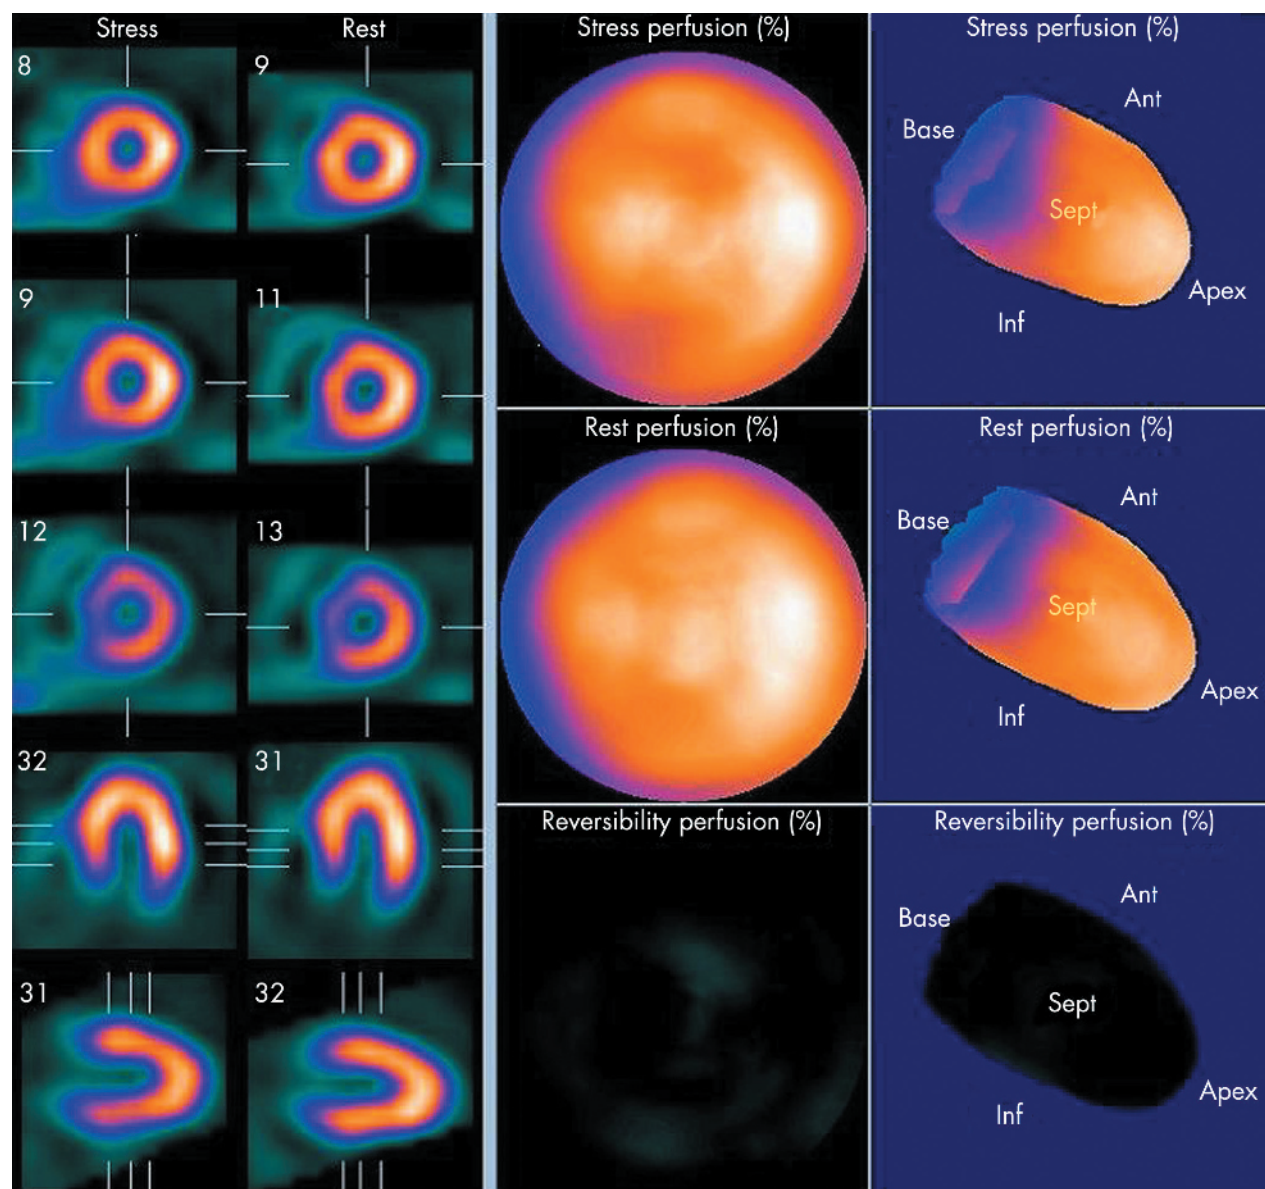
Sixty year old female, presented with typical chest pain and a positive exercise test. She underwent myocardial perfusion scintigraphy (MPS). Above are selected tomographic images and polar plots acquired after adenosine stress and following a rest injection of a ^{99m}Tc myocardial perfusion tracer. Images show normal myocardial perfusion after stress and rest, confirmed by the polar plots and the absence of any reversible perfusion on the subtraction image (lower right image).
